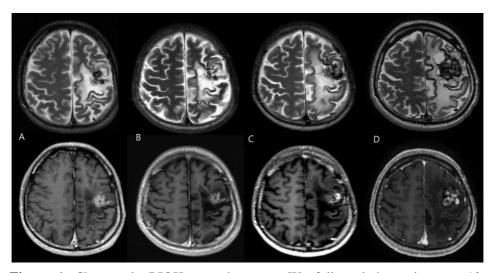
Changes in RIOH over the years. We followed the patient no. 12 regularly after GKRS. A) MRI scan 2.5 years after angiography confirmed total obliteration of AVM nidus. MRI showed RIOH and perilesional edema at the left parietal lobe. He did not complain of neurologic symptoms. Thus, we observed the patient regularly without treatment. B) MRI scan 4 years after initial diagnosis of RIOH. C) MRI scan 10 years after initial diagnosis of RIOH. As the RIOH continued to grow, the surrounding edema aggravated. D) The patient had seizure 15.5 years after initial diagnosis of RIOH. MRI showed rapidly enlarged RIOH and severe edema. Therefore, surgical resection of RIOH was performed.
